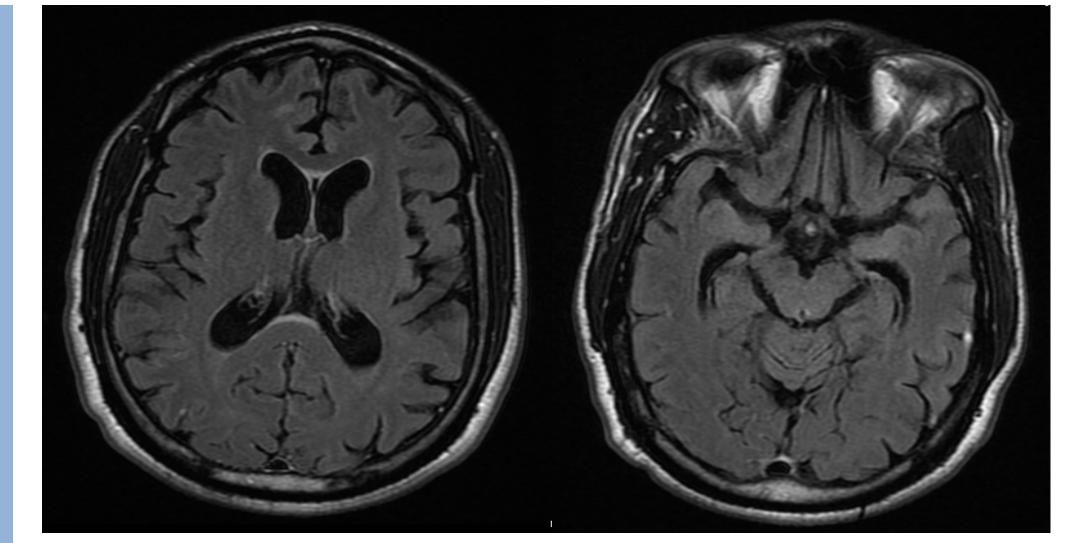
Brain FLAIR MR Images demonstrating non concordant age atrophy.
